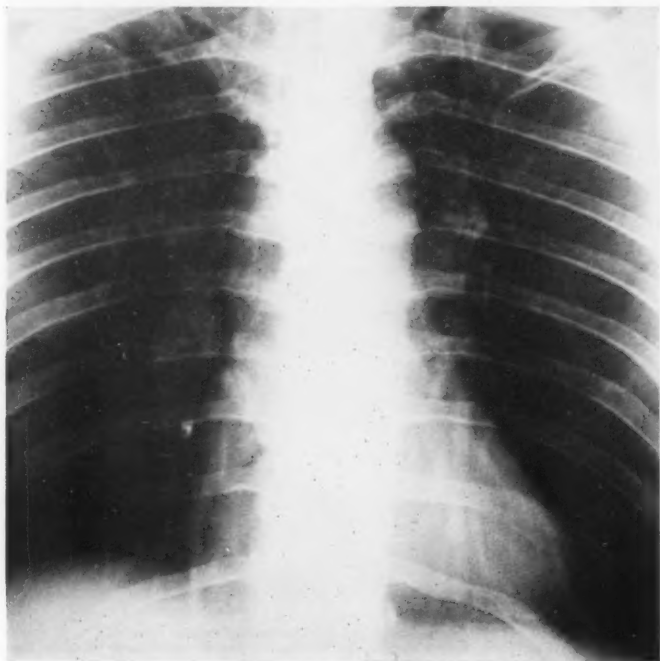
Postero-anterior roentgenogram revealing a dental inlay in the right lower lobe.
